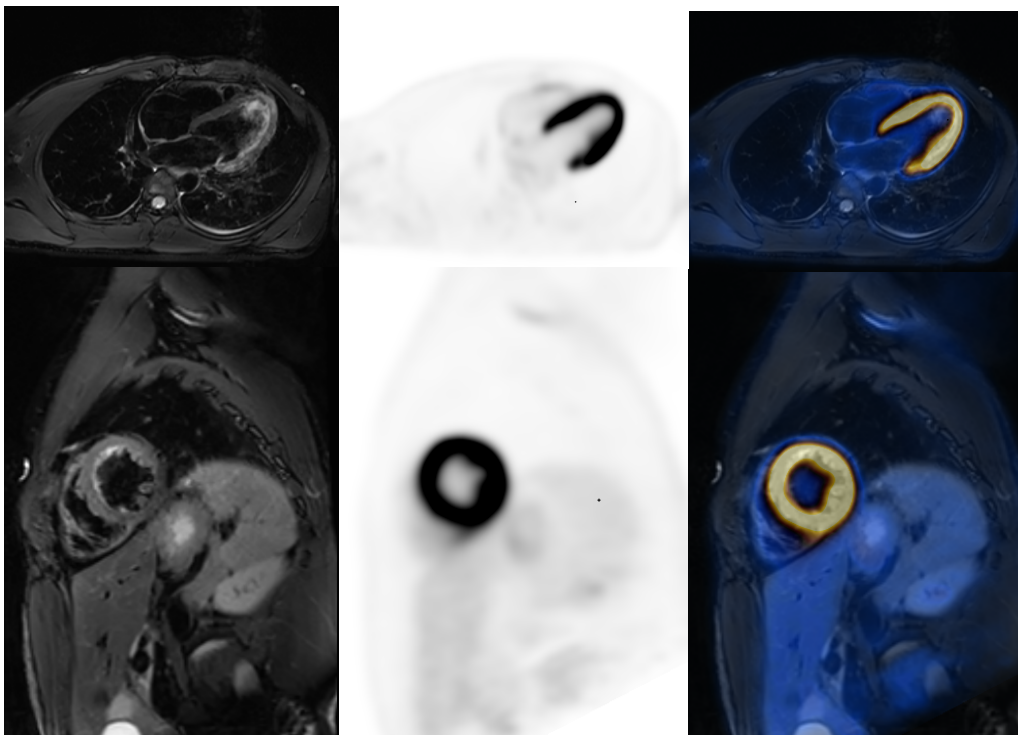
PET/MR images of a patient with myocarditis.
